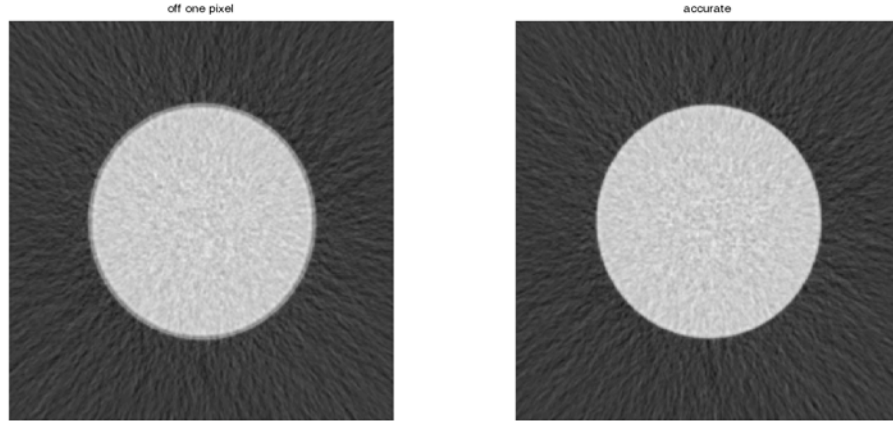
Example to show the importance of acquiring the accurate geometry of the breast CT system. On the right is the accurate reconstruction. On the left is the one reconstructed with the central ray off by a single pixel.
